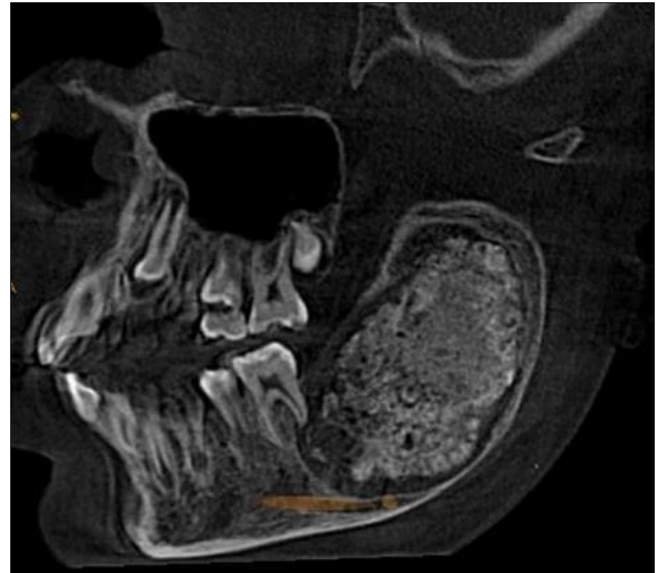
Reconstructed OPG View of CBCT Showing The lesion is extending from supero-inferiorly distal of 46 to 6mm short of the sigmoid notch, with a dimension of approx. 57.5mm and AP from medial border of anterior 1/3rd of ramus to the 2 cm from angle of mandible with dimension approx. 31.1mm
